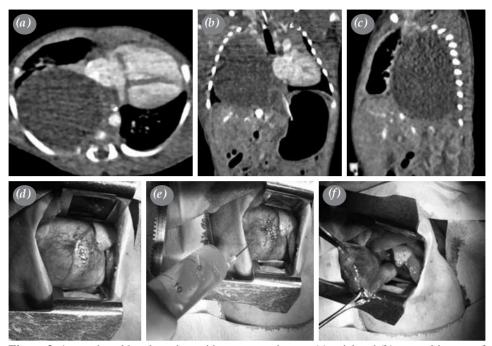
A two-day-old male patient with gastroenteric cyst; (a) axial and (b) coronal images of thoracic computed tomography. (c) Content of cyst and (d-f) contents have been emptied after cyst wall.
